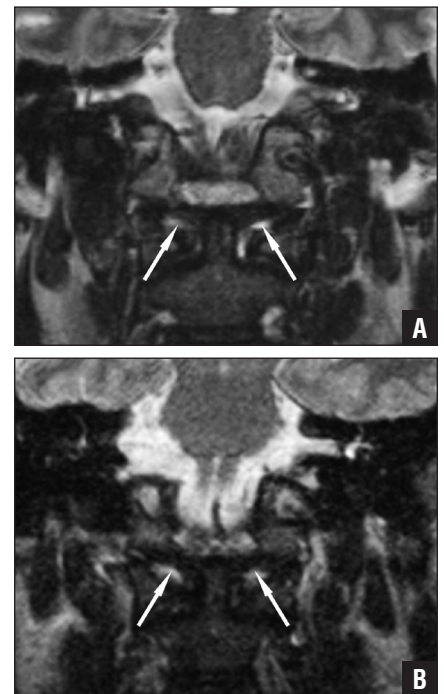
Three-T (A) and 1.5-T (B) magnetic resonance images showing the alar ligaments (arrows), which were classified as homogeneous, hypointense, and horizontal orientated with a convergent shape.
